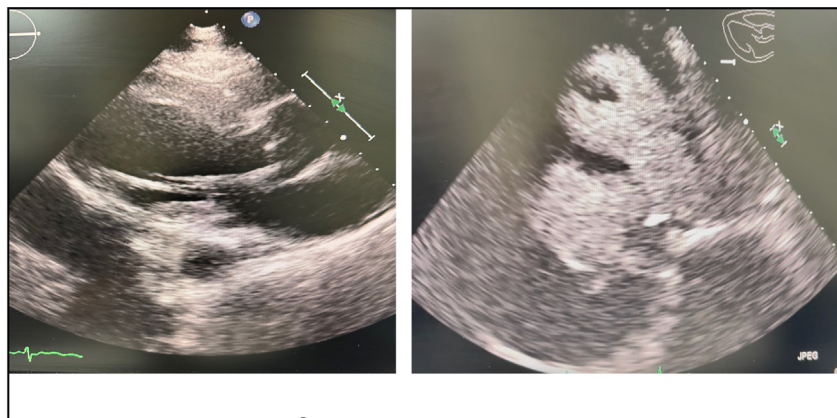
2D-Echocardiogram depicting a pseudoaneurysm in the posterior aspect of the left ventricle which is better delineating with contrast.
